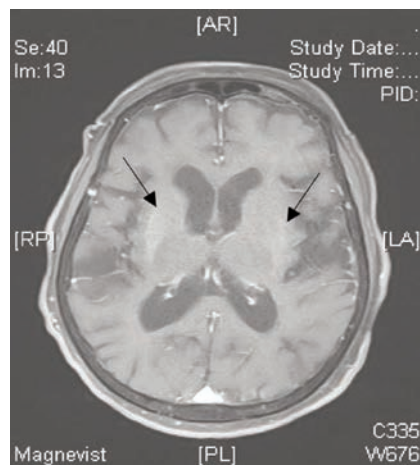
Gadolinium-enhanced brain magnetic resonance imaging shows hyperintensity signal over bilateral putamen regions in T1 weighted imaging.
